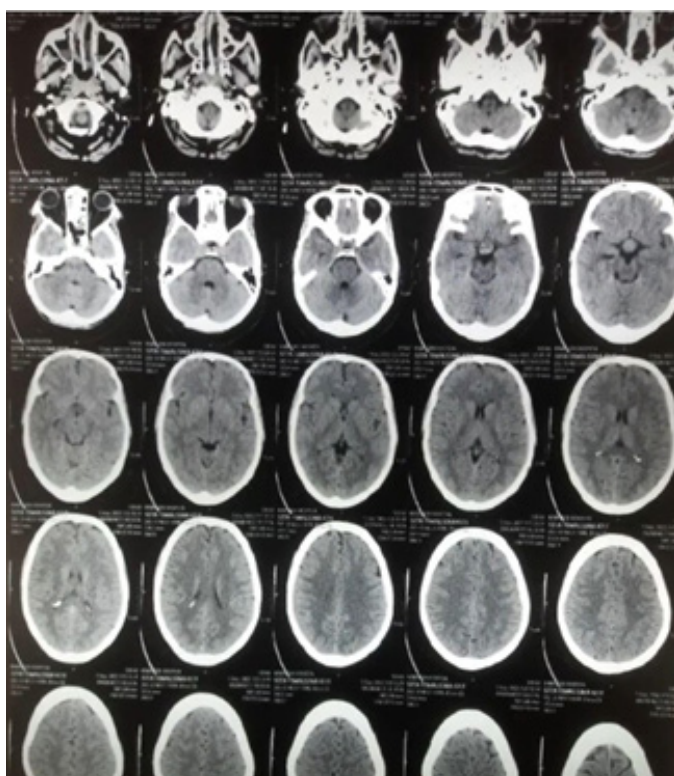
Post Operative CT Brain
